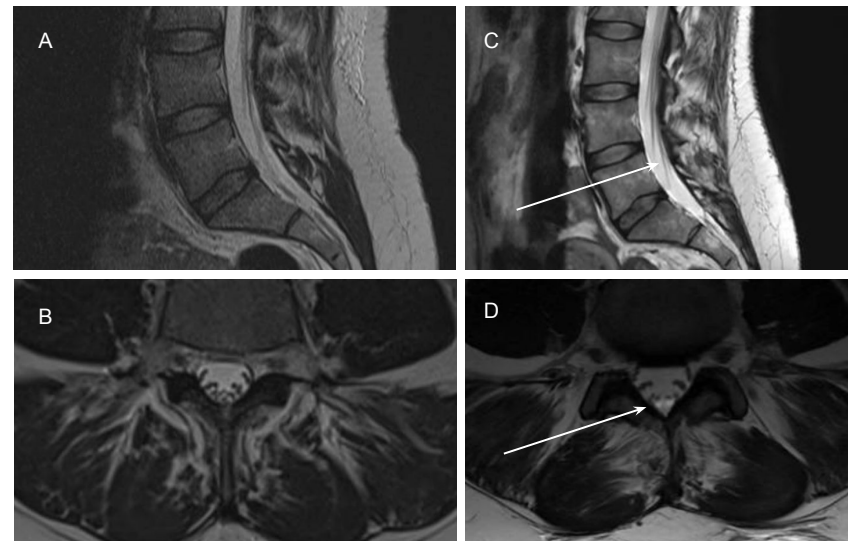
Interval cauda equina enhancement seen on MRI T2 TSE sequence at L4-5 at PPD 4 (A,B) and PPD25 (C,D).
